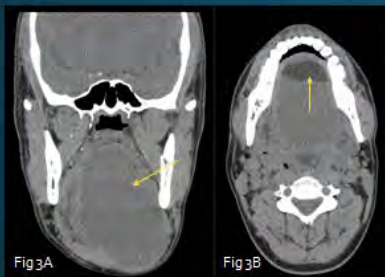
(A) Coronal CT at the level of the mandibular body shows an isodense cystic lesions which extends from the floor of the mouth well below the mandible. It has a thick, irregular rim. (B) The axial image shows a fat-fluid level within the lesion, not conspicuous on coronal views. There is mass effect on the adjacent structures. These findings indicate the layer cellular debris and proteinaceous material found in an extracranial epidermoid cyst.
